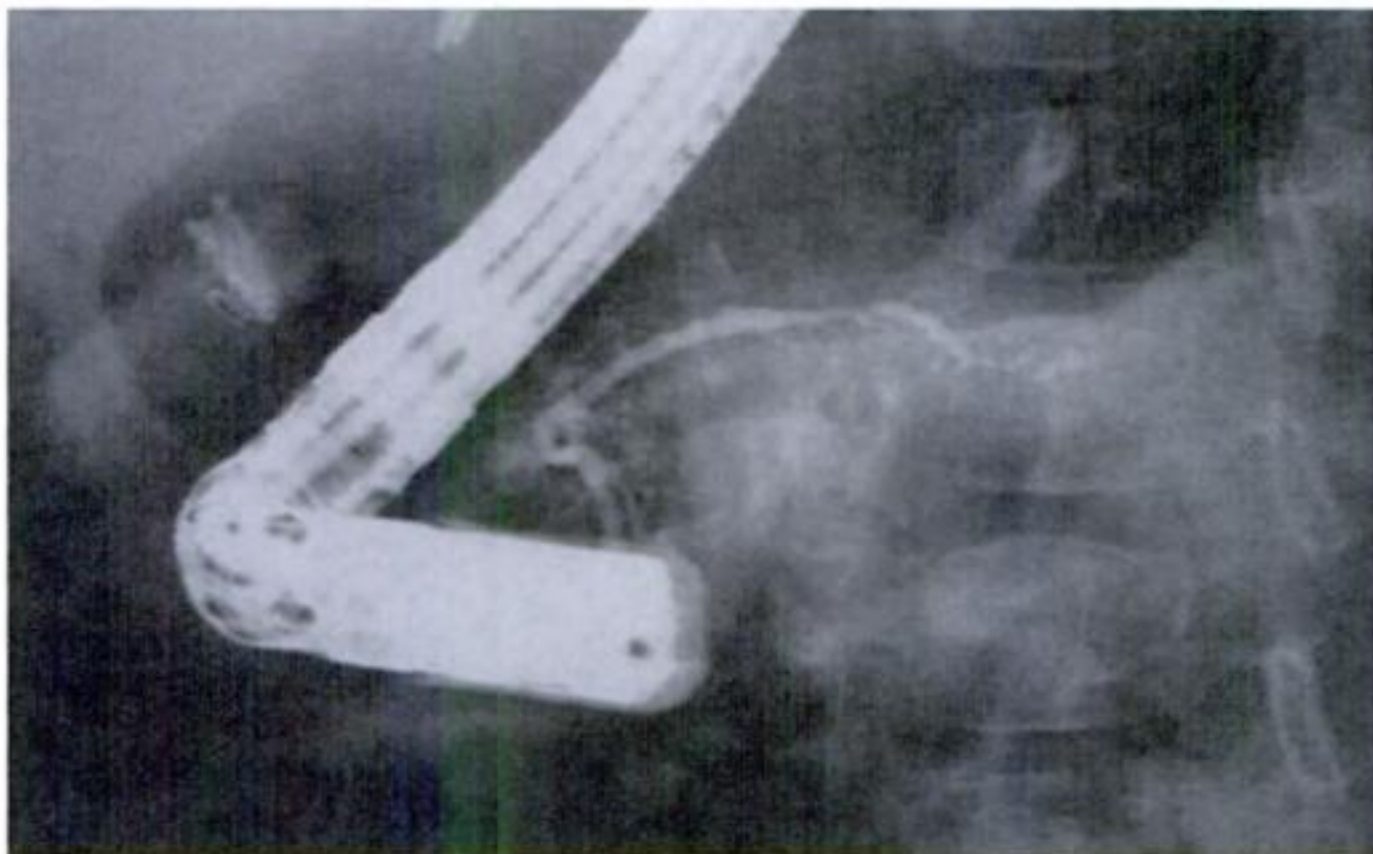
Chronic pancreatitis in a 3-year-old child suffering from intractable diarrhea (primary epithelial dysplasia) under parenteral nutrition. Recurrent bouts of pancreatitis following a cholecystectomy are not elucidated by ultrasonography and magnetic resonance cholangiopancreatography. Endoscopic retrograde cholangiopancreatography shows moderate irregularities of the main pancreatic duct better seen in the tail.
